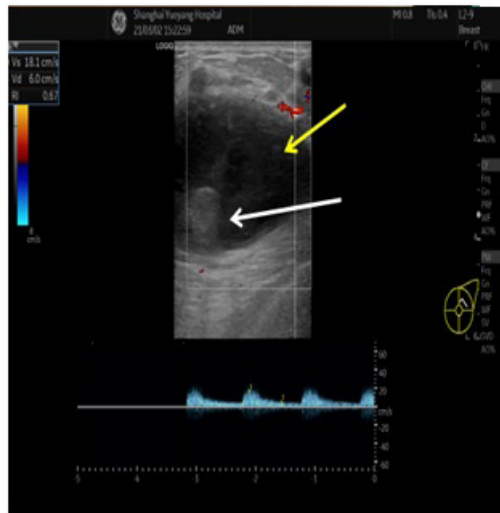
Ultrasound image presented a hypoechoic area with uneven echo inside and clear boundary in the outer upper quadrant of left breast, the size was 5.2×4.2×5.0 cm (yellow arrow), and a fine floating echo signal with several weak hypoechoic lumps located outside that area. Among them, the largest was 2.0×1.6×1.8 cm (white arrow). The RI indicated blood supply equaled 0.67.
